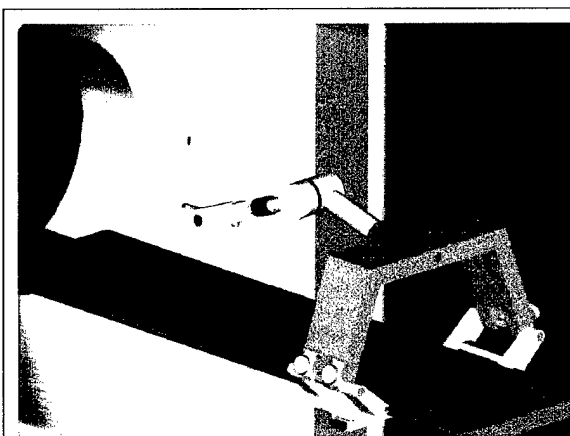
CAD Rendering of Robot Mount and Arm on CT Table
